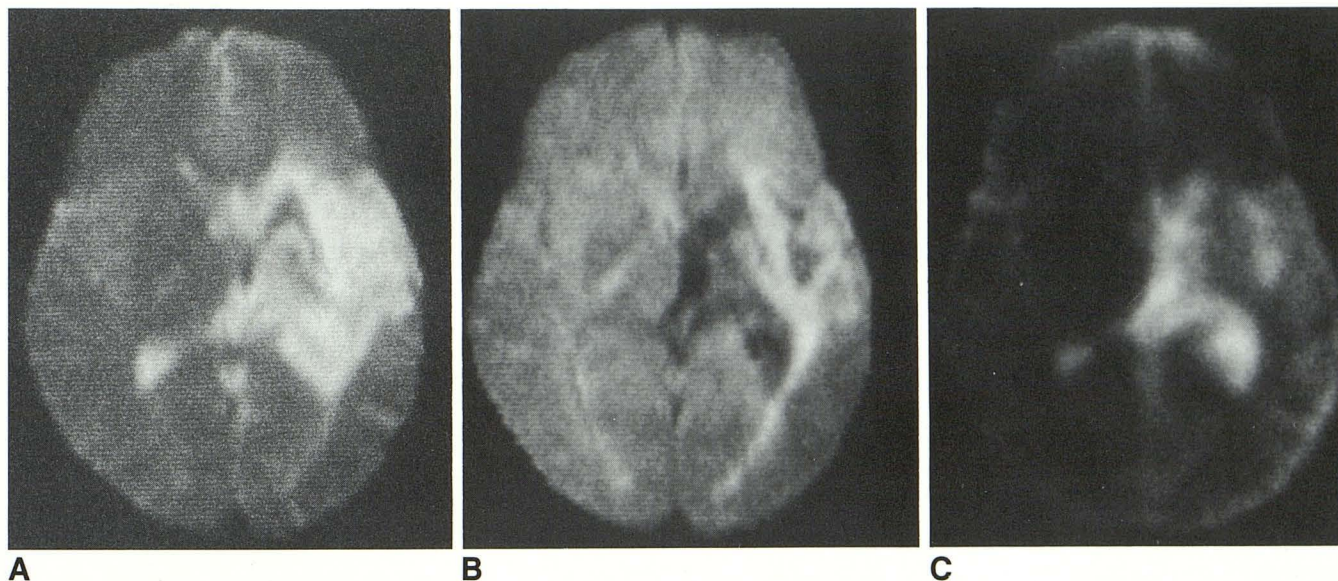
A 22-year-old stroke patient with marked subcortical and cortical infarction was studied 4 years after the initial ischemic attack. The T2-weighted image (A) shows hyperintensity in a large region in the left putamen and insula area. In the diffusion-weighted image (B), tissues with high ADC have greater signal attenuation than tissues with low ADC. The large region with increased T2 is now resolved into subregions with high diffusion (that appear dark) and areas with lower diffusion (that appear bright). The lesion can be separated from the CSF in the ventricles, since the CSF now becomes dark due to diffusion-related signal attenuation. Within the lesion, there are two small areas that also show significant signal attenuation. In the calculated ADC map (C), bright areas now correspond to regions with high diffusion. It can be seen that CSF has a high ADC due to flow, while the lesion has increased ADC relative to normal brain tissue.
